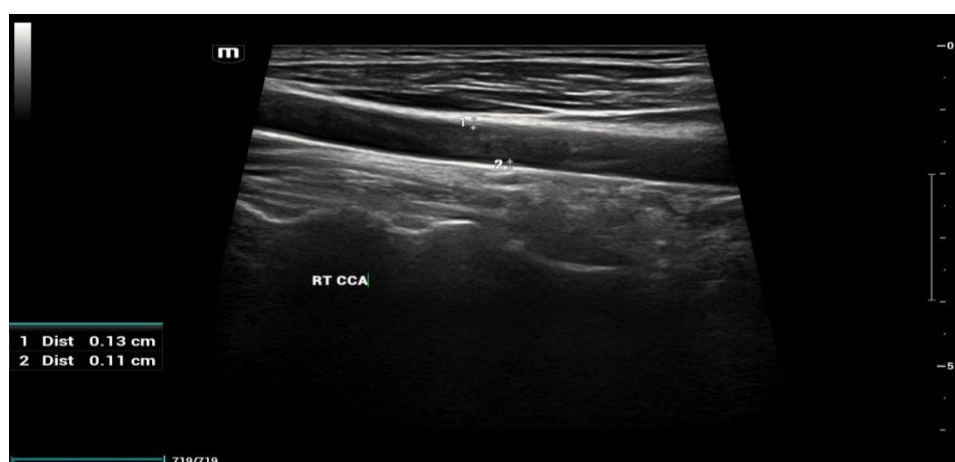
Right CCA – B-mode longitudinal ultrasound image demonstrating CIMT measurement.
